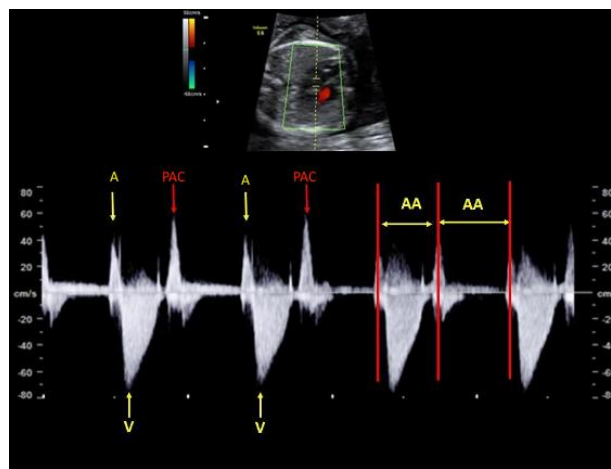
Atrial bigeminy. Pulsed mitral and aortic Doppler in which an irregular atrial rhythm is identified due to a sinus atrial beat (A) conducted to the ventricles (V) followed by a premature atrial contraction (PAC) not conducted to the ventricles, observing a short-long AA interval alternately.
